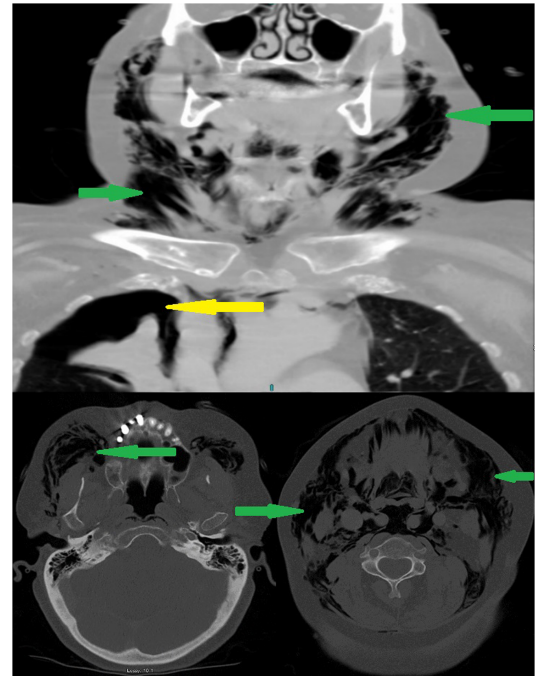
CT scan of the head, neck and chest showing right-sided pneumothorax (yellow arrow) and extensive subcutaneous emphysema (green arrow).
